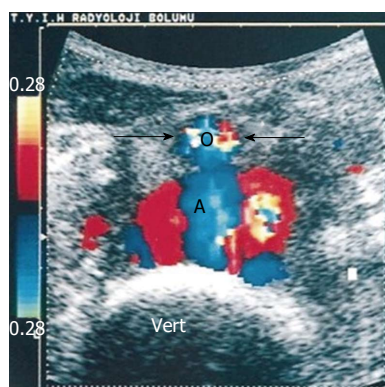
Transverse color Doppler sonogram shows turbulent flow in the pseudoaneurysm. Note the anterior displacement of the normal-sized aorta (arrows and AO) and the drape of the posterior wall of the pseudoaneurysm over the anterior aspect of the spine (vert)^[84].
